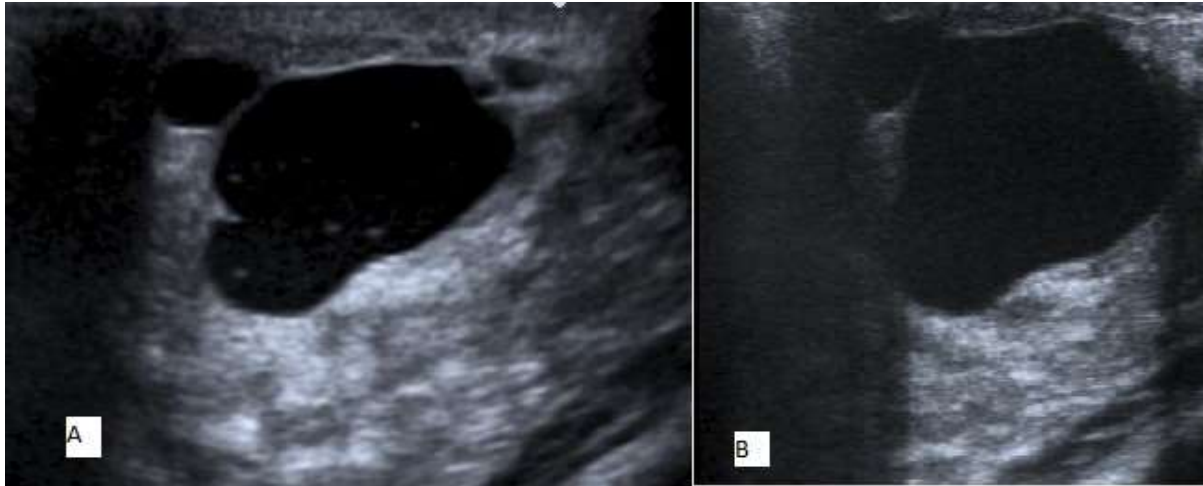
A. Ultrasonography of right breast showing a well-circumscribed oval cystic mass internal ecogenities. B. Control Ultrasonography of the right breast after treatment.
